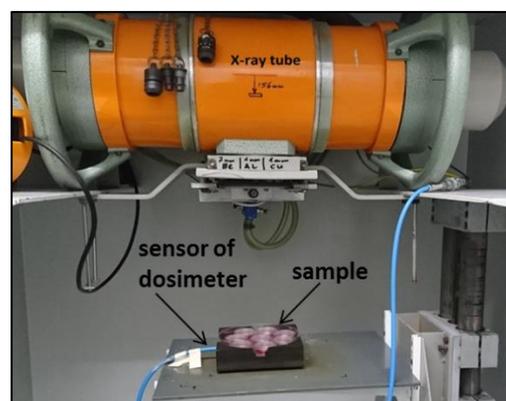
X-ray irradiation of the samples. For the irradiation experiments samples and the sensor of dosimeter were placed below the exit window of X-ray tube
